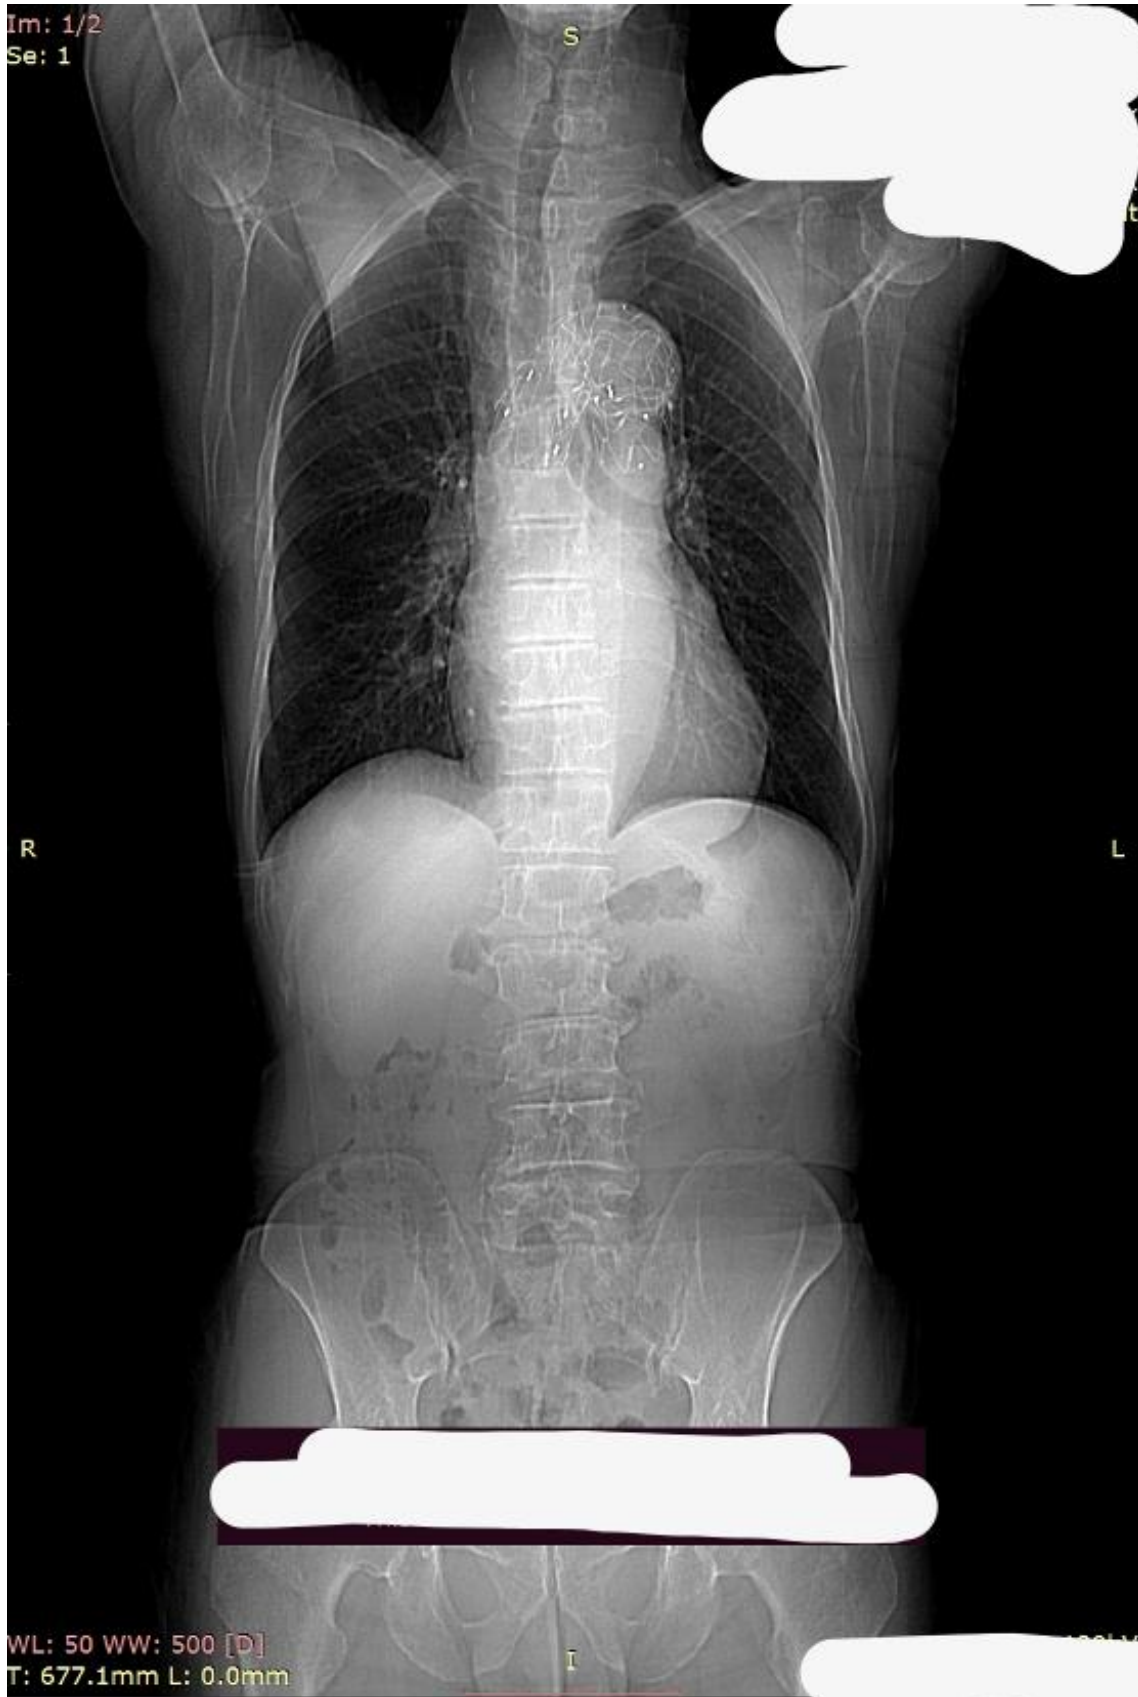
Coronal view of CTA post TEVAR.
